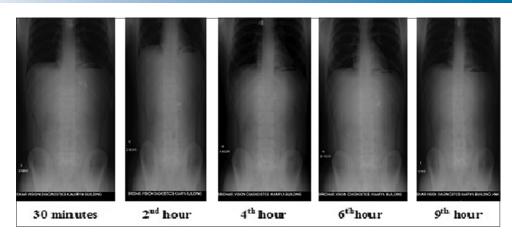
Radiographic pictures of human volunteers taken at different time intervals
